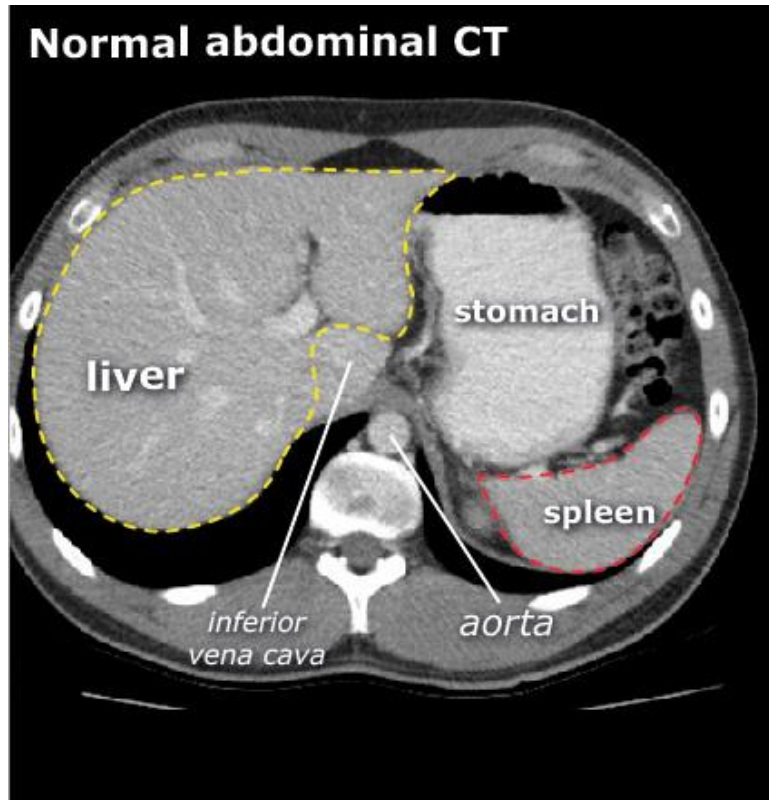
Normal liver CT
